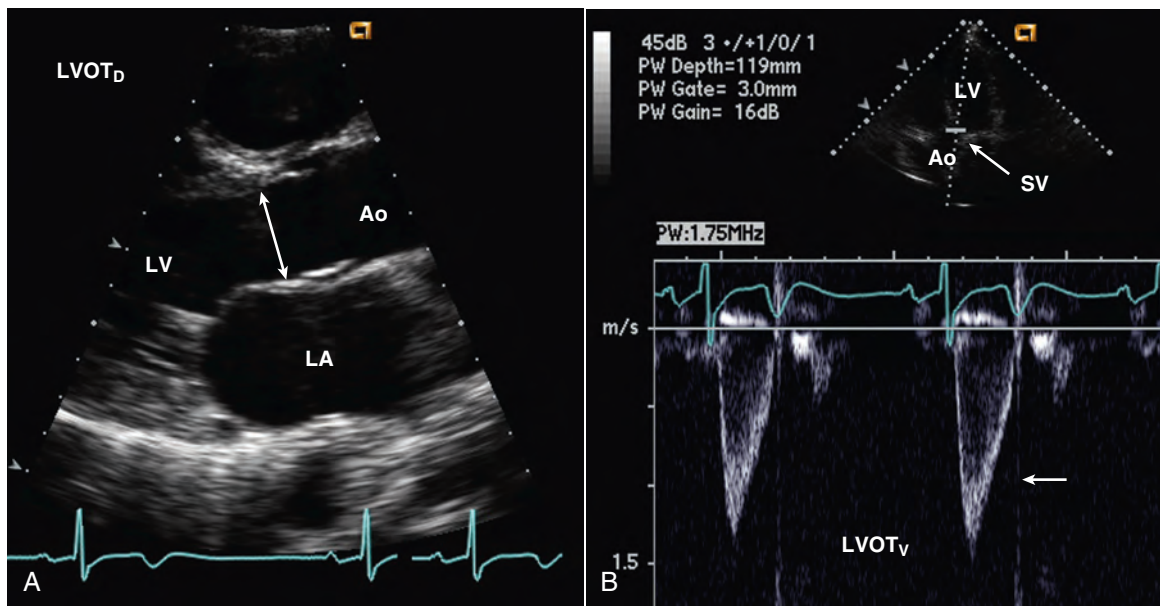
Doppler left ventricular outflow stroke volume calculation. (A) LV outflow tract diameter ($LVOT_D$) measurement from a parasternal long-axis view and (B) the pulsed Doppler recording of LV outflow just proximal to the aortic valve (Ao) from an apical approach for stroke volume calculation. The aortic valve closing click (*arrow*) on the outflow tract velocity ($LVOT_V$) recording ensures that the sample volume (SV) location is immediately adjacent to the valve, corresponding with the site of outflow tract diameter measurement.
